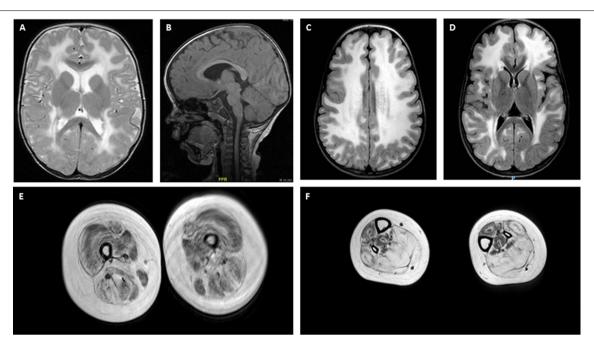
Brain and muscle imaging findings in LAMA2-RD. (A-D) Typical brain MRI findings in LAMA2-RD with abnormal appearance of myelin with sparing of the U fibers seen on T2 axial images (A,C,D). T1 sagittal image (B) demonstrates evidence of occipital polymicrogyria, which has been observed in some LAMA2-RD patients and may predispose to occipital lobe seizures. Muscle MRI of the upper leg (E) and lower leg (F) in a 9-year-old patient with complete merosin deficiency with evidence of abnormal signaling in most muscles with relative sparing of the sartorius and gracilis muscles (E). In the lower leg, the muscles of the anterior compartment seem relatively spared compared to muscles of the posterior compartment, namely the soleus and gastrocnemius muscles, which demonstrate the apparent replacement of muscle with fibrofatty tissue.
